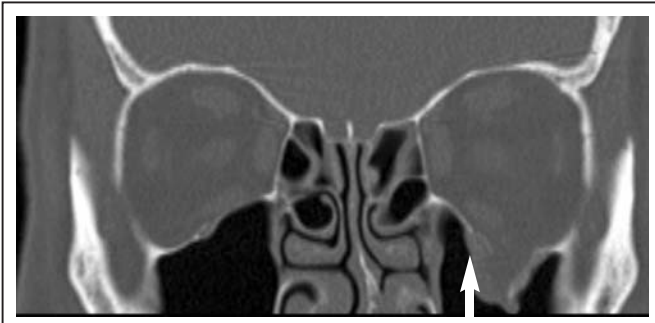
Coronal CT showing orbital tissue prolapse into the left maxillary antrum
